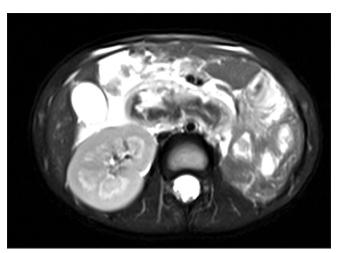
Magnetic resonance imaging showing duodenal haematoma
